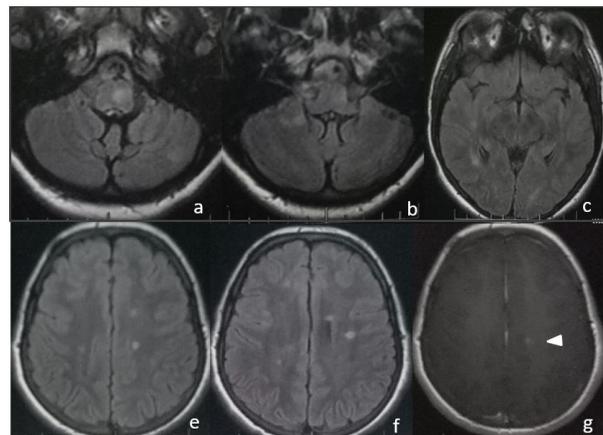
Brain MRI showing multiple FLAIR hypersignals in sub and supra tentorial white matter.
